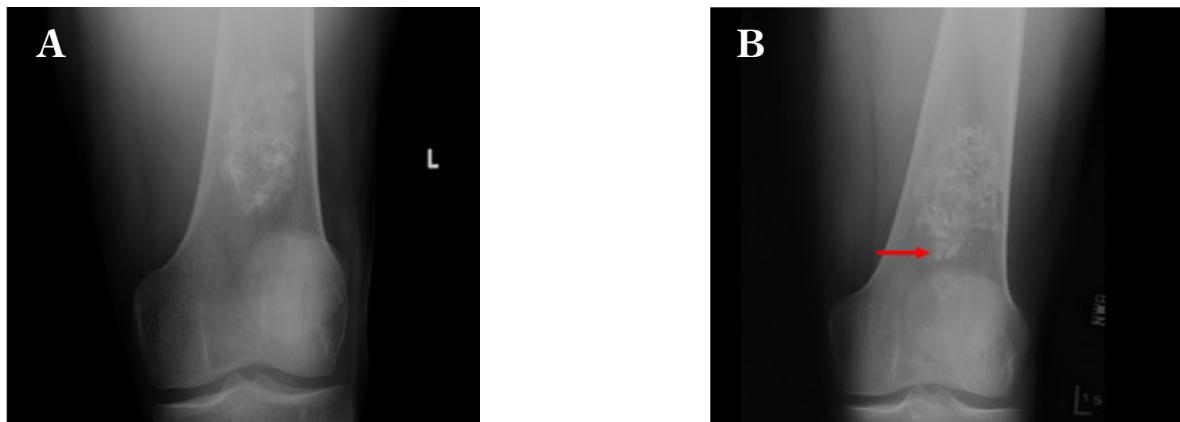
Growing enchondroma. Plain radiographs of the left femur of a 49 year-old male with a painful distal femoral shaft lesion. At 25 months follow-up, the lesion size grew from 7 cm (A) to 7.43 cm (B) inferiorly and showed endosteal scalloping with cortical erosion.
